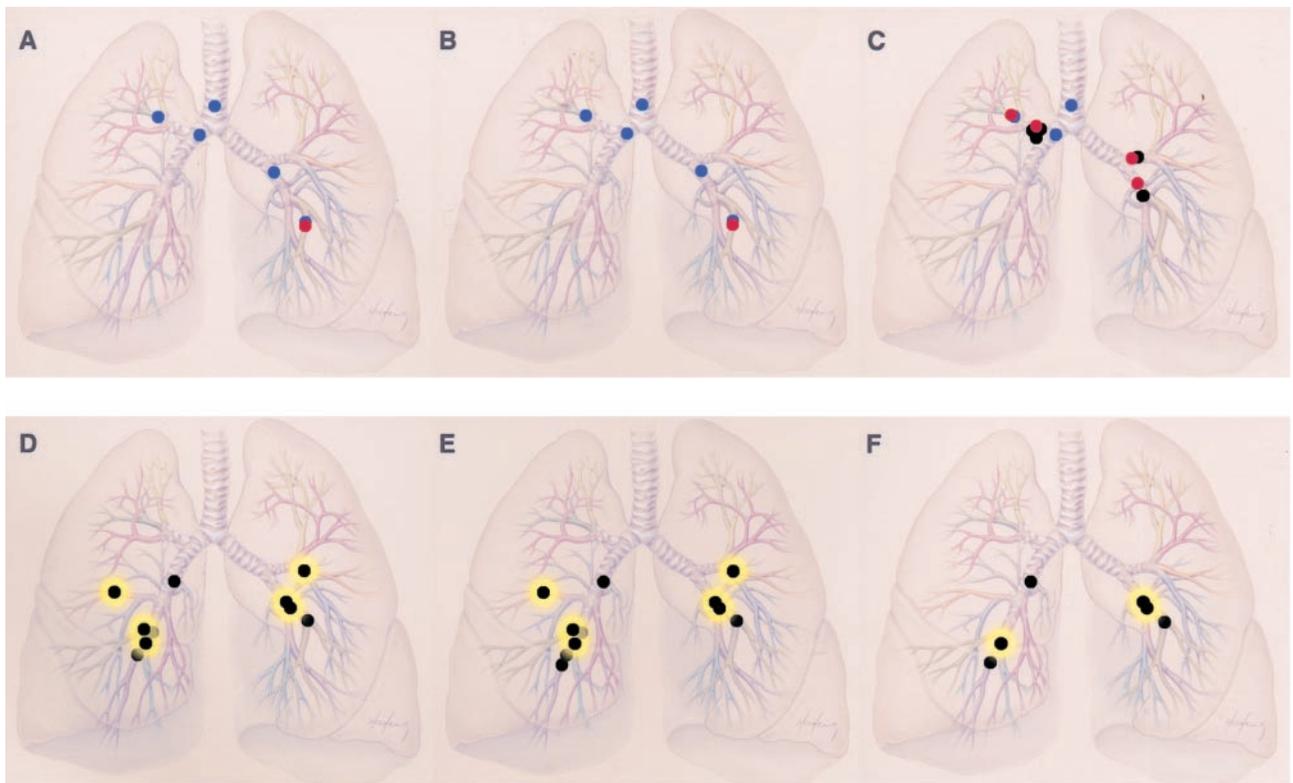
Location of FN lesions determined by SHR-CT scan (top left, A), VB (top middle, B), and CT scan (top right, C). Location of additional distal lesions not reachable by FB but nevertheless visualized by SHR-CT scan (bottom left, D), VB (bottom middle, E), and CT scan (bottom right, F). A black circle represents an obstructive lesion, a red circle represents an endoluminal lesion, and a blue circle represents a mucosal lesion. Lesions highlighted in yellow were confirmed to be positive by pathology.
